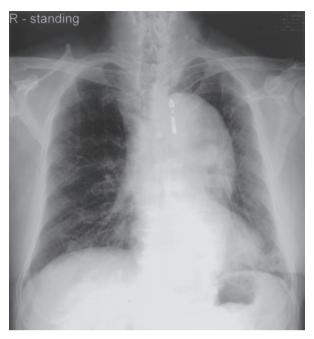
Chest radiography showing widening of the mediastinum, suggesting thoracic aortic aneurysm
